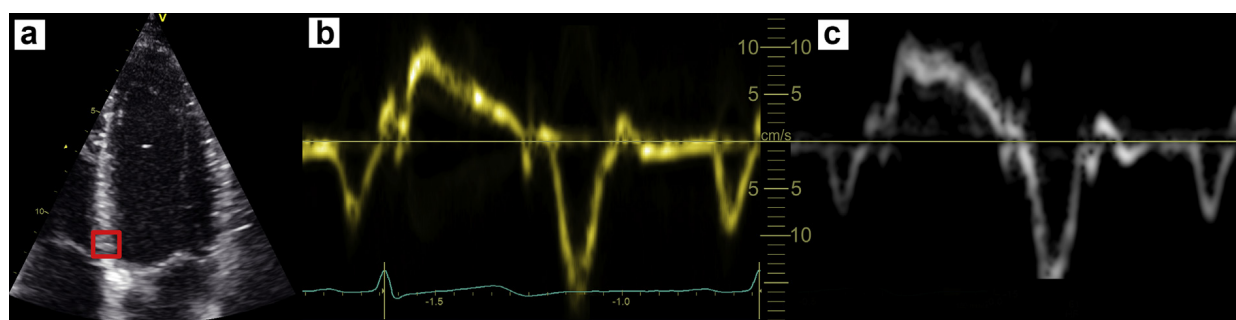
(a) B-Mode with sample volume. (b) Conventional pulsed wave tissue Doppler from sample volume in (a). (c) Retrospective spectral Doppler from ultrahigh-frame-rate tissue Doppler imaging data from sample volume in (a).
